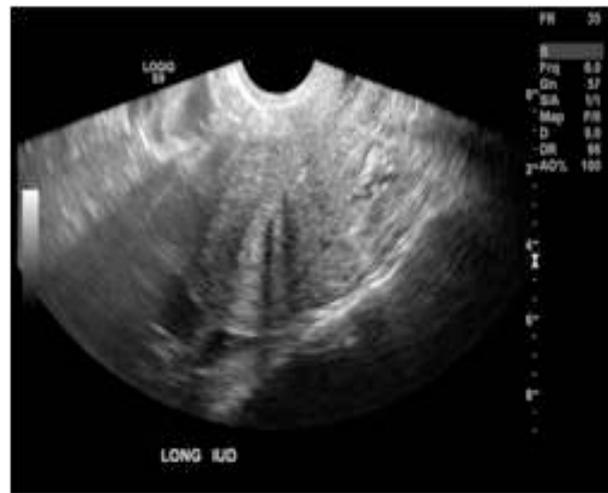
Sagittal 2D Ultrasound showing the intracavitary presence of the IUD.
